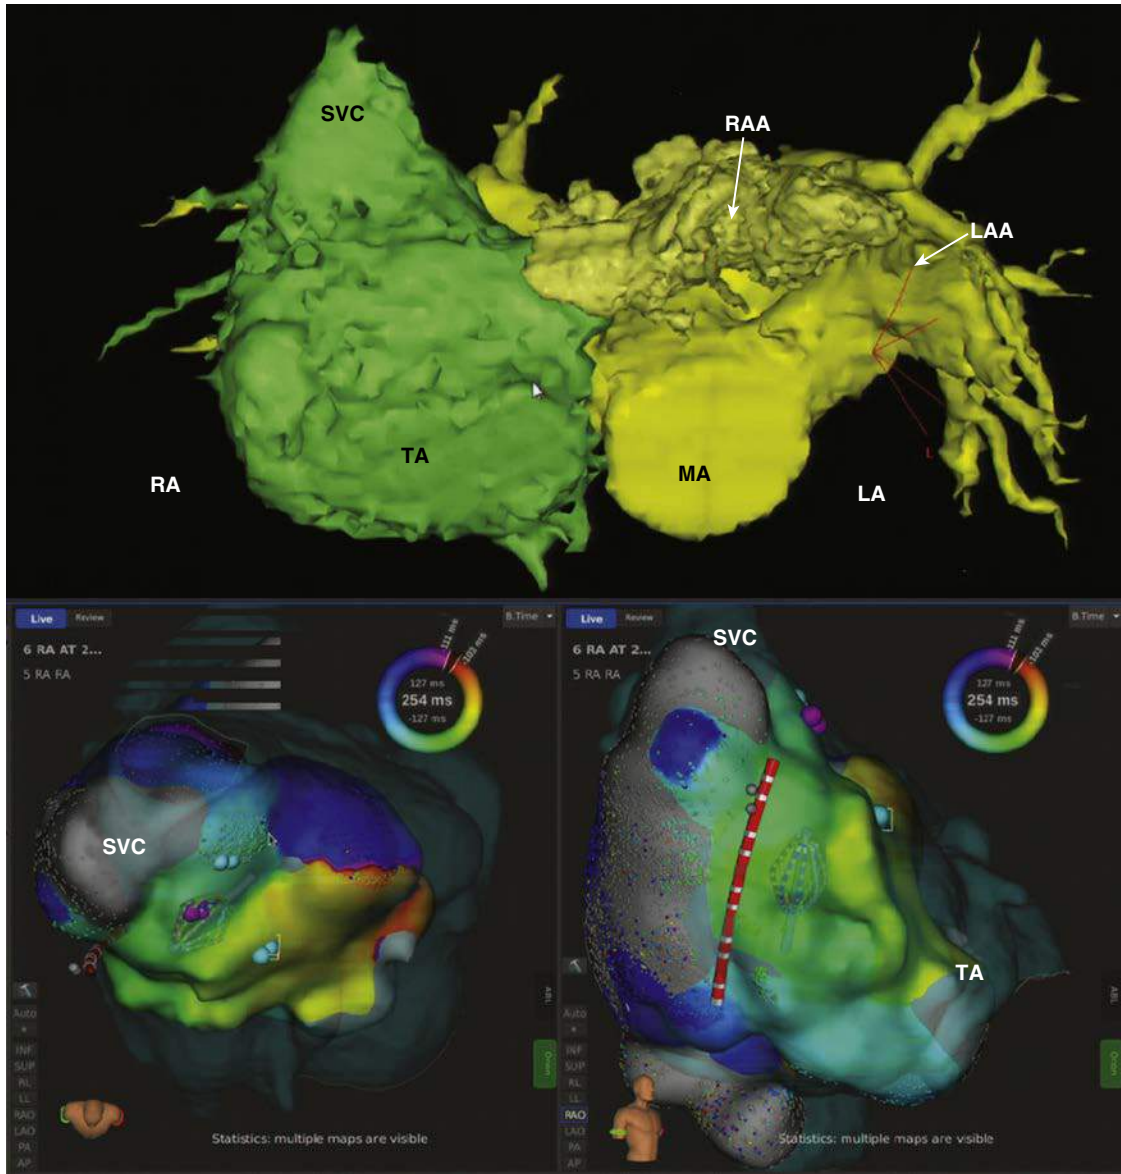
Example of a patient with juxtapositioned atrial appendages and atrial tachycardia. *Top panel*, three-dimensional (3D) reconstruction from contrast computed tomography (CT) scan depicting the juxtapositioned right (RAA) and left atrial appendage (LAA). *Bottom left panel*, full reconstruction of the atrial activation sequence using the sequential multielectrode mapping system Rhythmia (Boston Scientific). The reentry circuit rotates around a centrally located scar (gray area) with the critical isthmus between the scar and the superior vena cava (SVC). *Right bottom panel*, same as left but displayed in right anterior oblique (RAO) projection to display large scar area (in gray) in the free wall of the massively dilated right atrium. Red catheter displayed served as the timing reference during the mapping process with the Orion basket catheter. LA, Left atrium; MA, mitral annulus; RA, right atrium; TA, tricuspid annulus.
